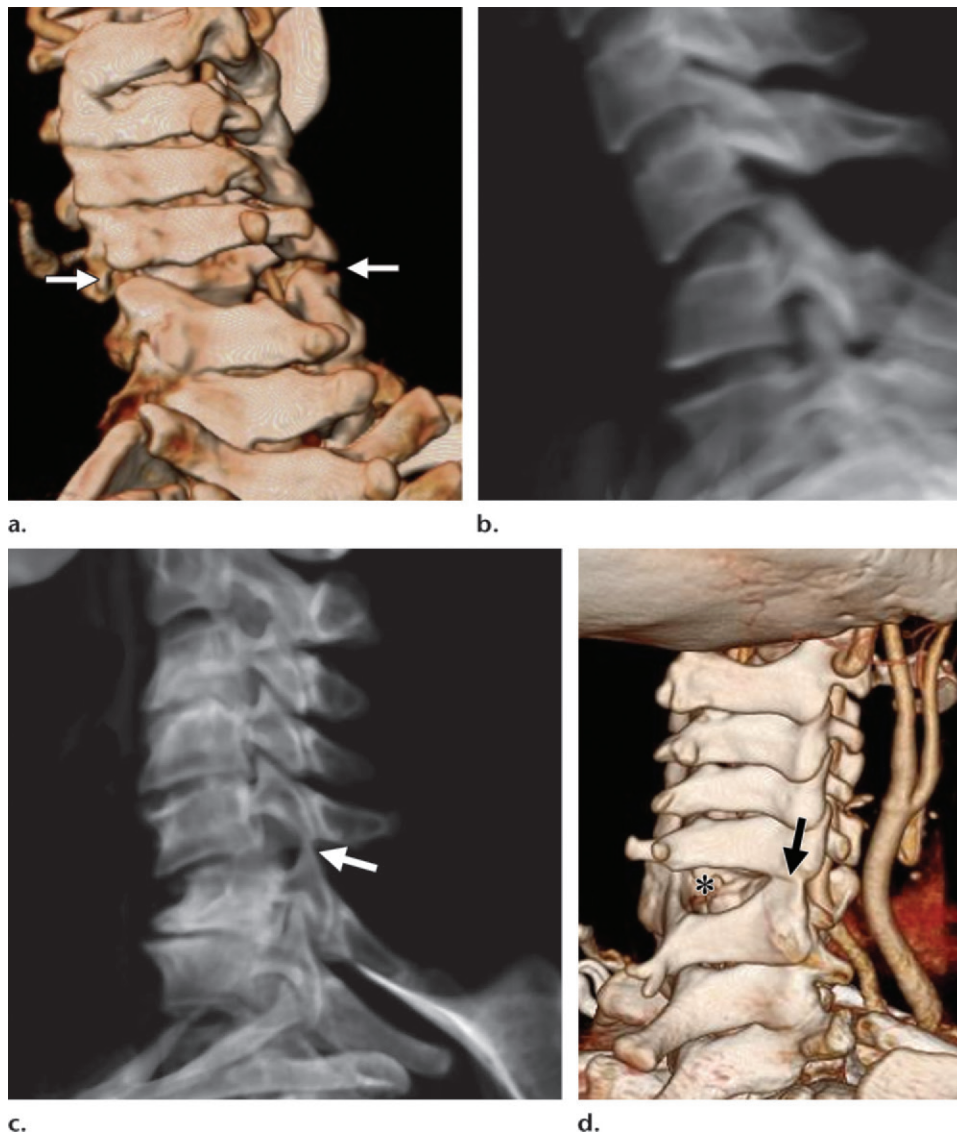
Flexion-distraction injuries in two patients. (a) Oblique volume-rendered CT image of a 39-year-old woman after an MVC shows bilateral C5-C6 facet distraction (arrows). (b) Sagittal “virtual radiograph” volume-rendered CT image of a 39-year-old woman (same patient as in a) shows C5-C6 kyphotic angulation and posterior disk space widening. (c) Sagittal “virtual radiograph” volume-rendered CT image of a 43-year-old woman who fell a short distance and landed on her head shows perched facets (arrow) at C5-C6, with focal kyphotic deformity. (d) Oblique volume-rendered CT image of a 43-year-old woman (same patient as in c) shows interspinous widening (*) associated with the C5-C6 facet perch (arrow).
